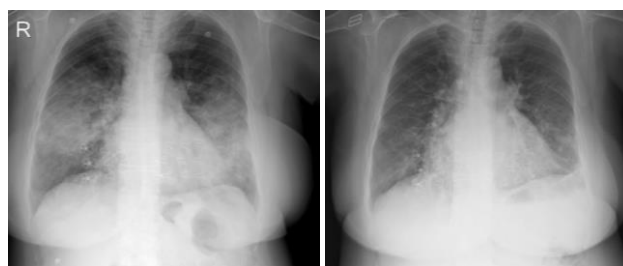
Posteroanterior chest radiographs at initial presentation (left) and at discharge (right). The admission image demonstrates bilateral perihilar and lower zone consolidations, consistent with DAH.
